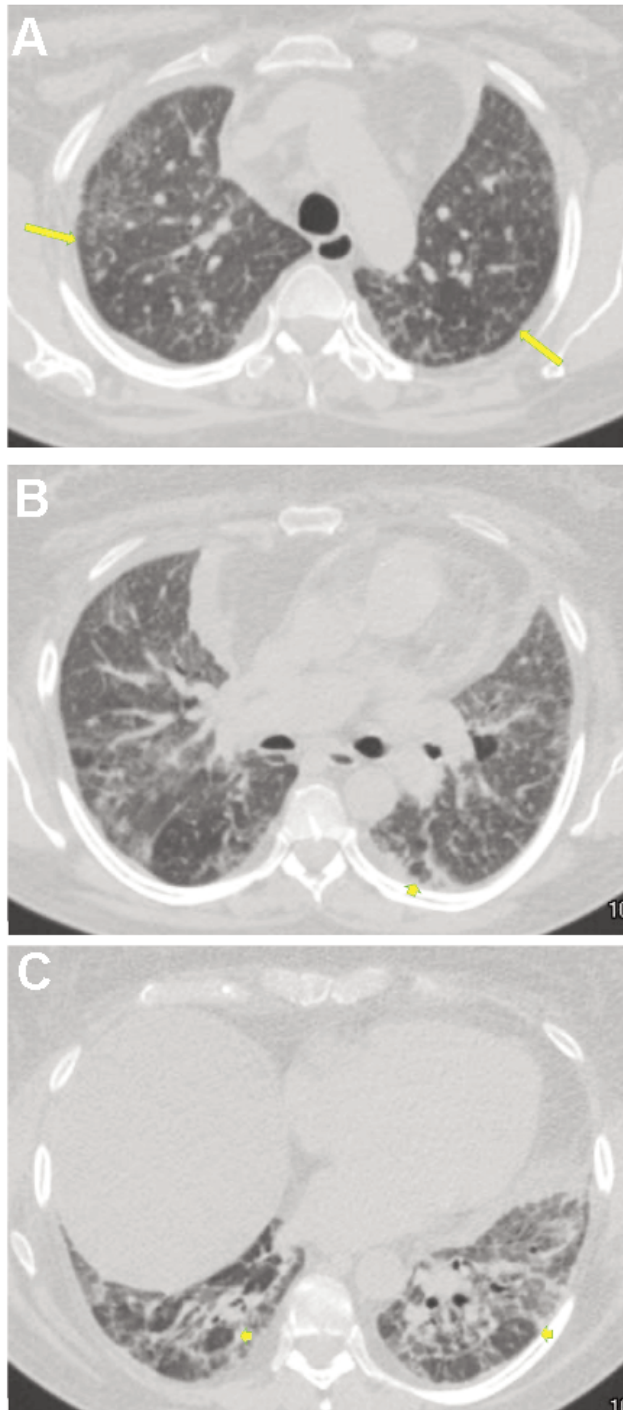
Axial HRCT images from a patient with anti-synthetase syndrome with myositis and ILD at the level of the aortic arch (A), below the carina (B), and just above the hemidiaphragms (C). Diffuse ground glass densities are present with areas of subpleural sparing (arrows) suggesting an NSIP pattern of lung injury. In the mid and lower lungs, more consolidative areas are noted, as well as areas of perilobular consolidation, suggesting an organizing pneumonia pattern of lung injury (arrowheads).
